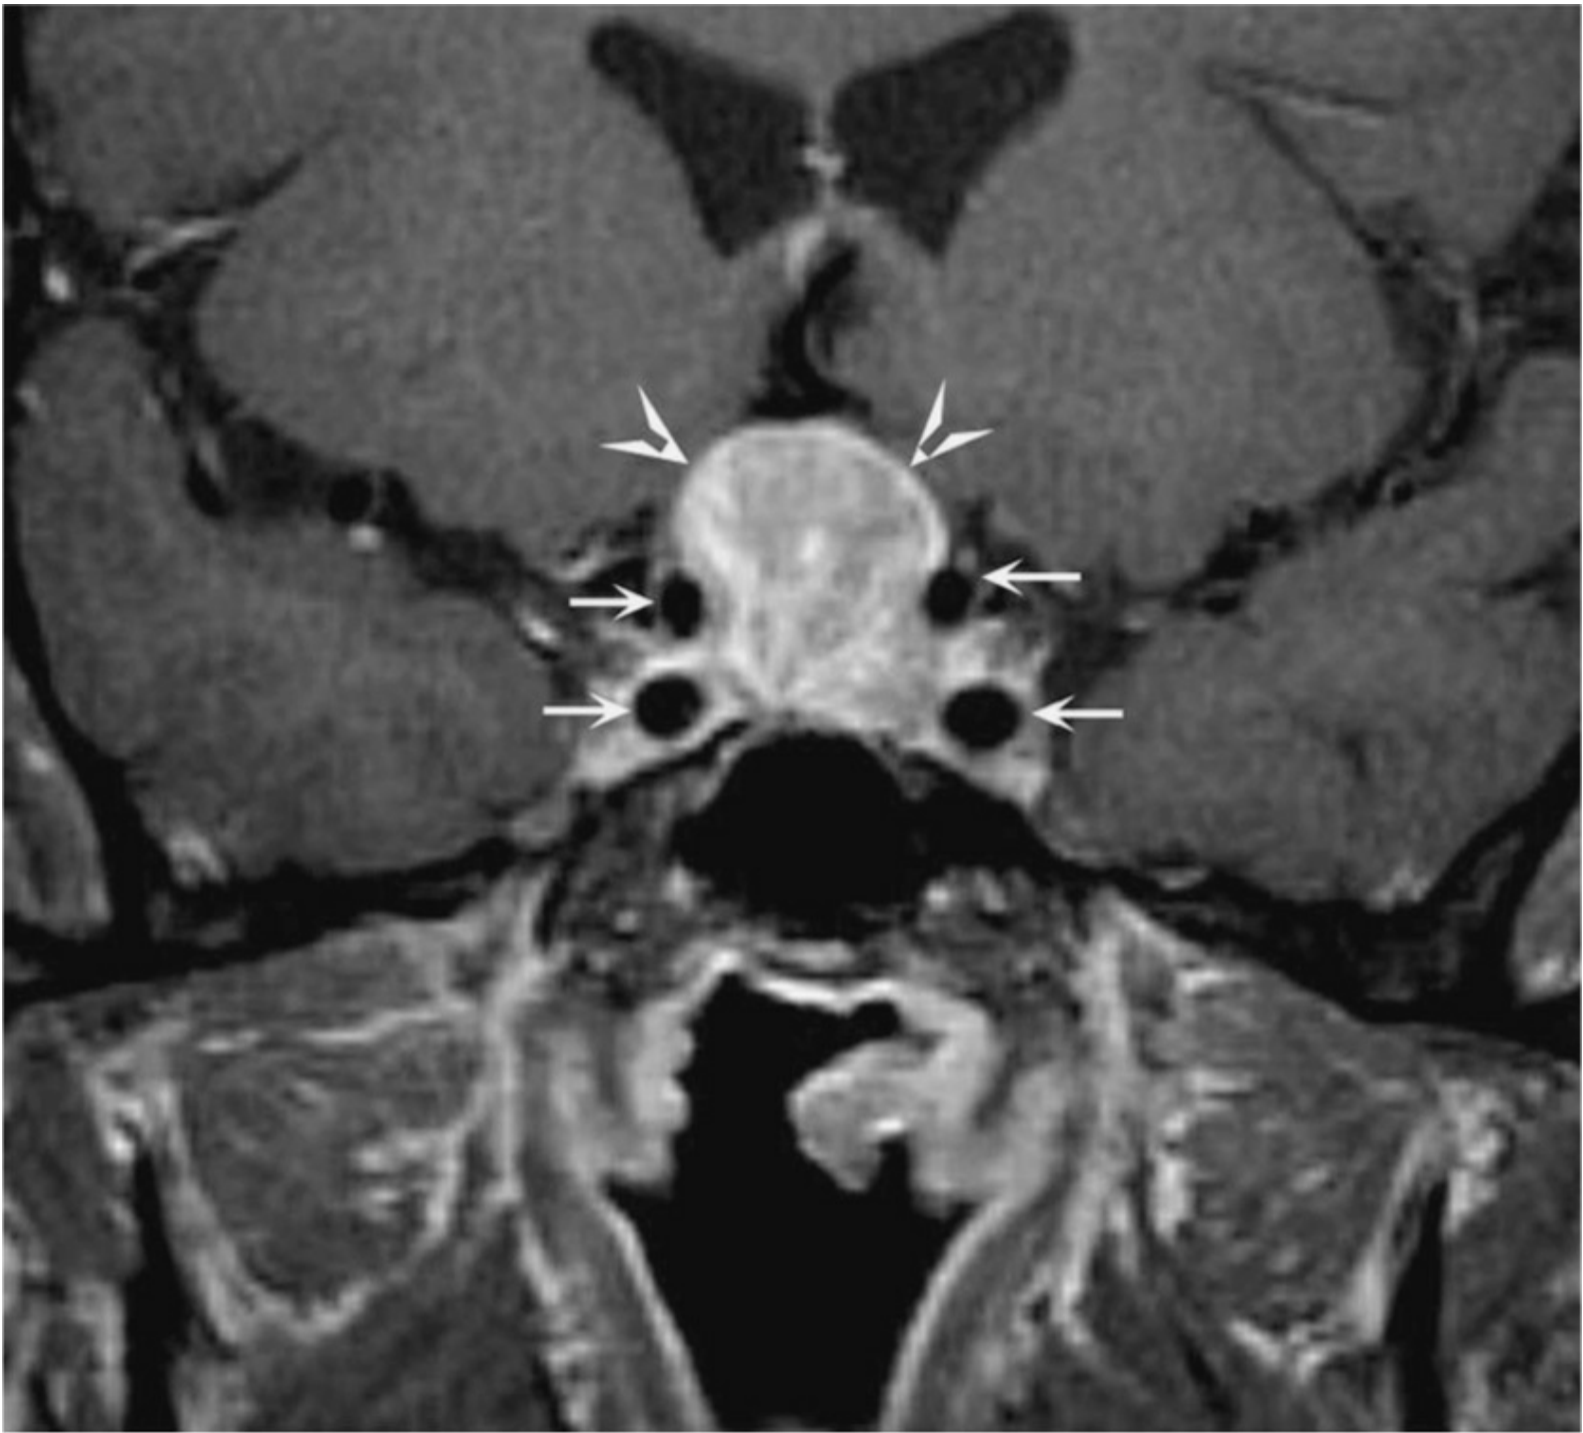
Coronal T1-weighted postcontrast magnetic resonance image shows a homogeneously enhancing mass (*arrowheads*) in the sella turcica and suprasellar region compatible with a pituitary adenoma; the *small arrows* outline the carotid arteries. (Reproduced, with permission, from Longo DL, Fauci AS, Kasper DL, et al, eds. *Harrison's Principles of Internal Medicine*. 18th ed. New York: McGraw-Hill; 2012.)
